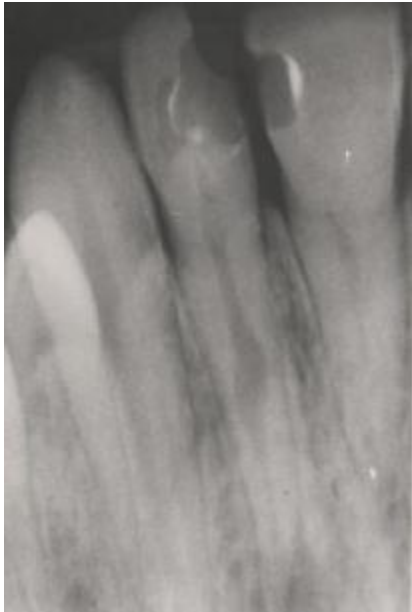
Preoperative radiograph
